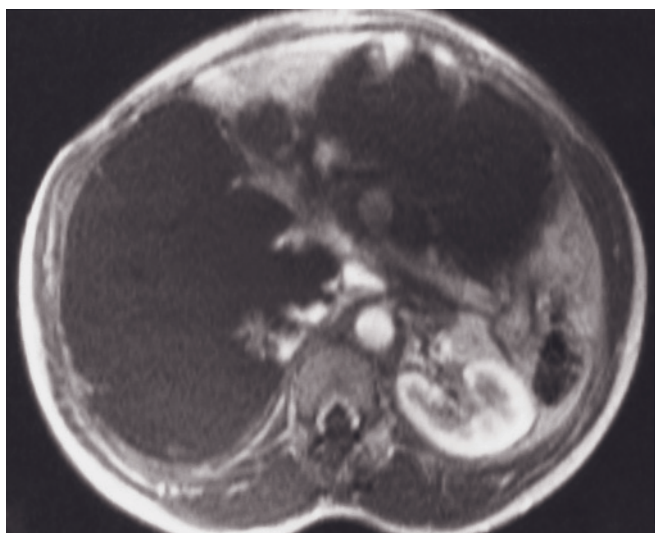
(Continued) Coronal T2-weighted SS-ETSE (e), transverse echo-train STIR (f), and immediate (g) and 5-min (h) post-gadolinium SGE images in a second patient. A massive lobulated lesion is present in the liver parenchyma that is predominantly high signal intensity on T2-weighted images (e, f), but with multiple low-signal strands, and demonstrates discontinuous nodular enhancement (g) with centripetal progression (h) after the administration of gadolinium. Regions of hypointense central scar persist on the late images (h). Low-signal-intensity linear strands are common on T2-weighted images in giant hemangiomas and represent bands of collagenous tissue. This patient underwent liver transplantation because of the extensive hepatic replacement by hemangiomas.
